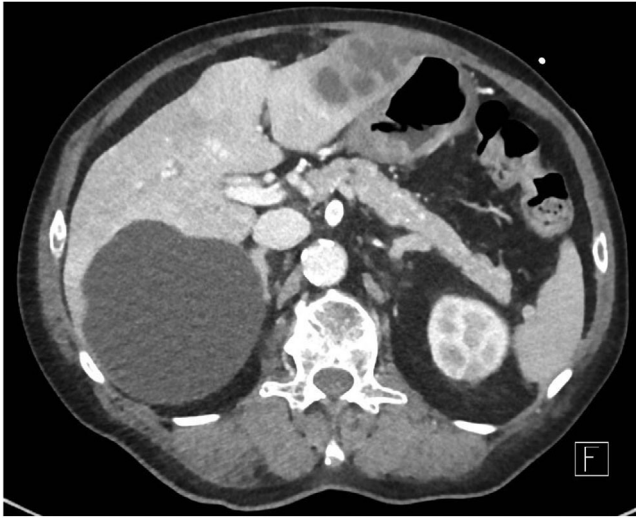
Five years prior: Positron emission tomography computed tomography of abdomen and pelvis with cystic lesions within right lobe of liver
